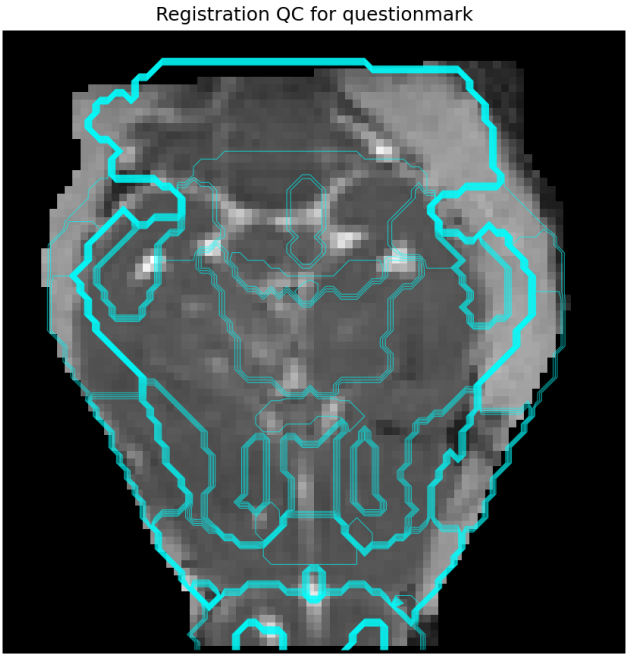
Visual quality control of brain atlas co-registration to a representative b0-weighted MR image from an Egyptian fruit bat. The overlaid cyan outlines demonstrate accurate anatomical alignment of brain regions, confirming the integrity of neuroimaging data used for regional morphometric feature extraction.
